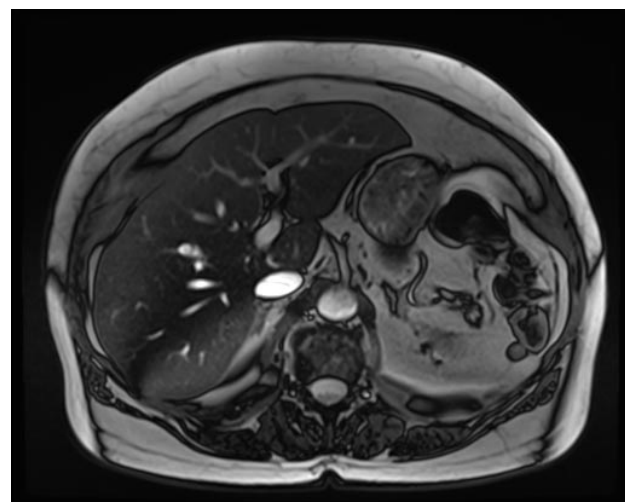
Multiple longitudinal cigarette-like lesions discovered in the liver. Magnetic resonance imaging (MRI). The authors' collection.
